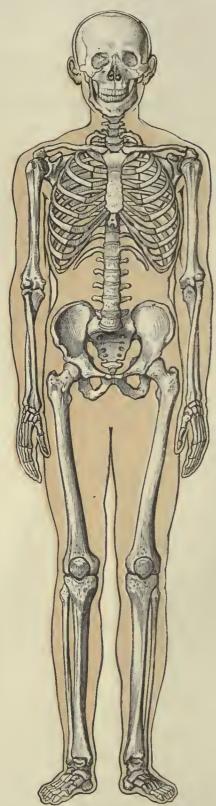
ANTERIOR ASPECT.
